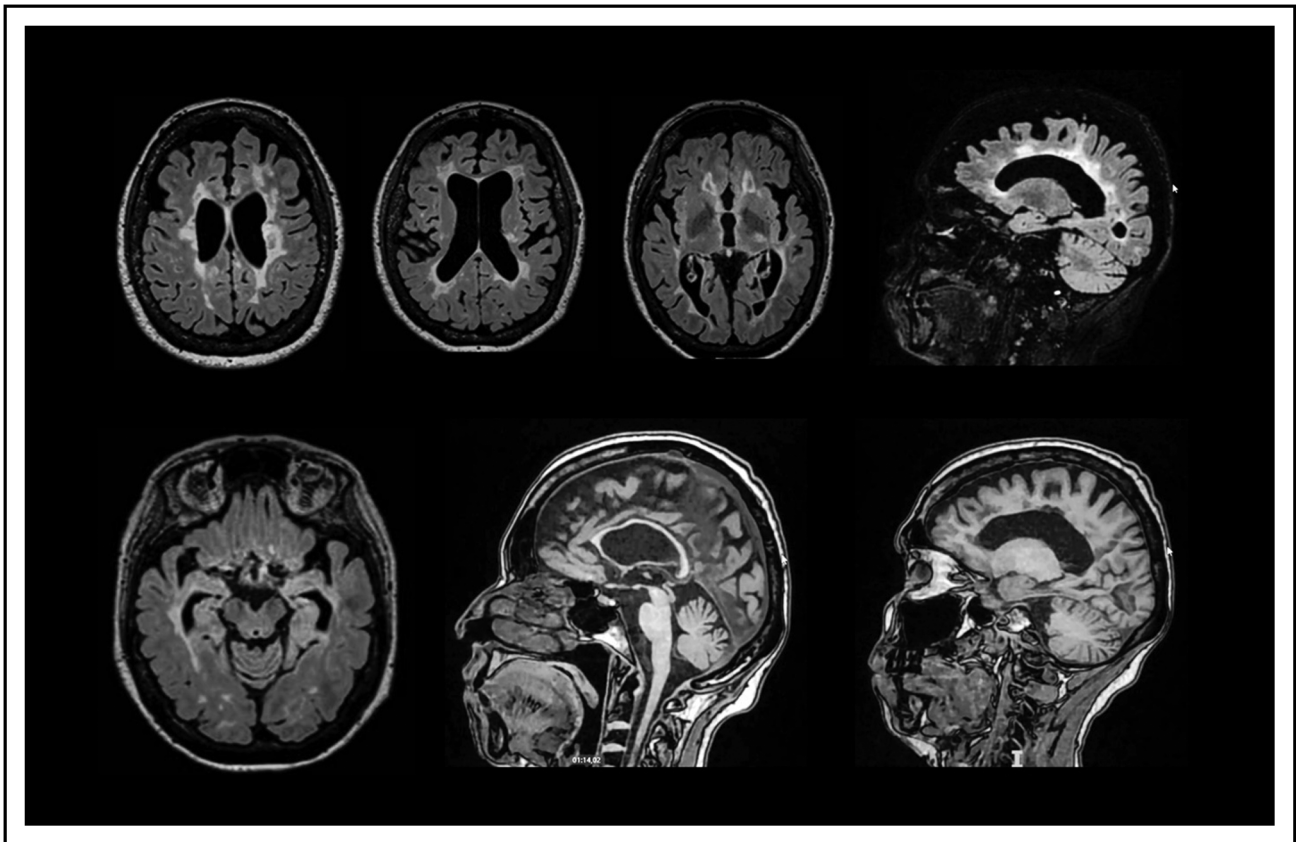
Structural Magnetic resonance imaging in the case of a 58-year-old woman suffering from secondary progressive multiple sclerosis, showing extensive white matter damage and loss of volume in both hemispheres with increased ventricular size. In T2 FLAIR sagittal projection, the Dawson fingerprint is present. Prominent demyelination and loss of cortical volume can be observed in the medial temporal lobes, bilaterally. The patient suffered from severe cognitive dysfunction affecting memory (visual, episodic, and semantic) and executive functioning (processing speed, planning, and inhibitory control).
